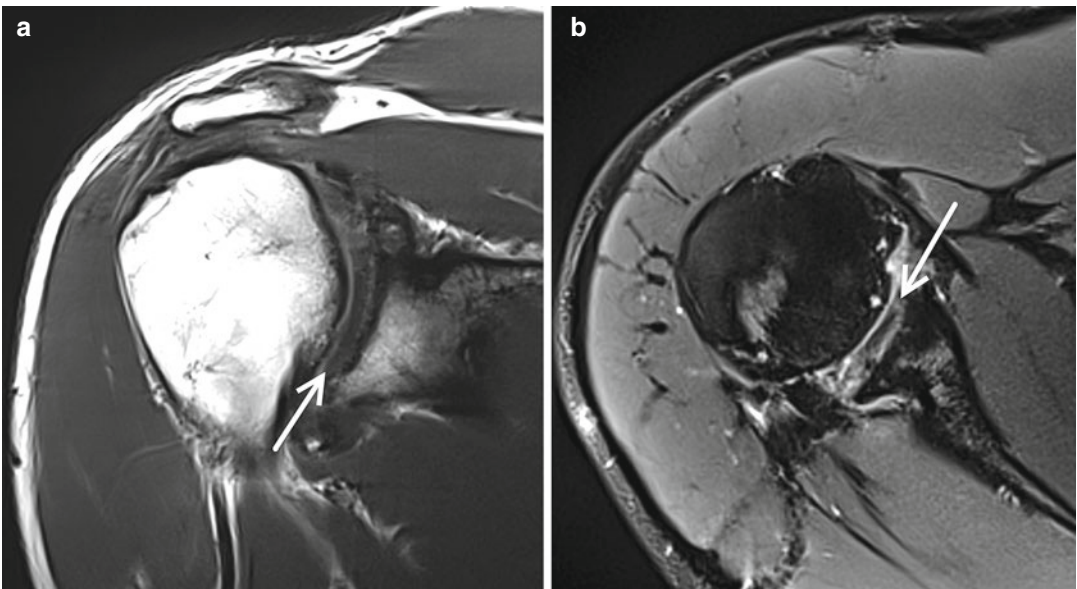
Right shoulder postoperative MRI 2 years after AGR in a 32-year-old chondrolysis patient shows the healed graft (white arrows) on (a) T1 coronal and (b) T2 axial images
